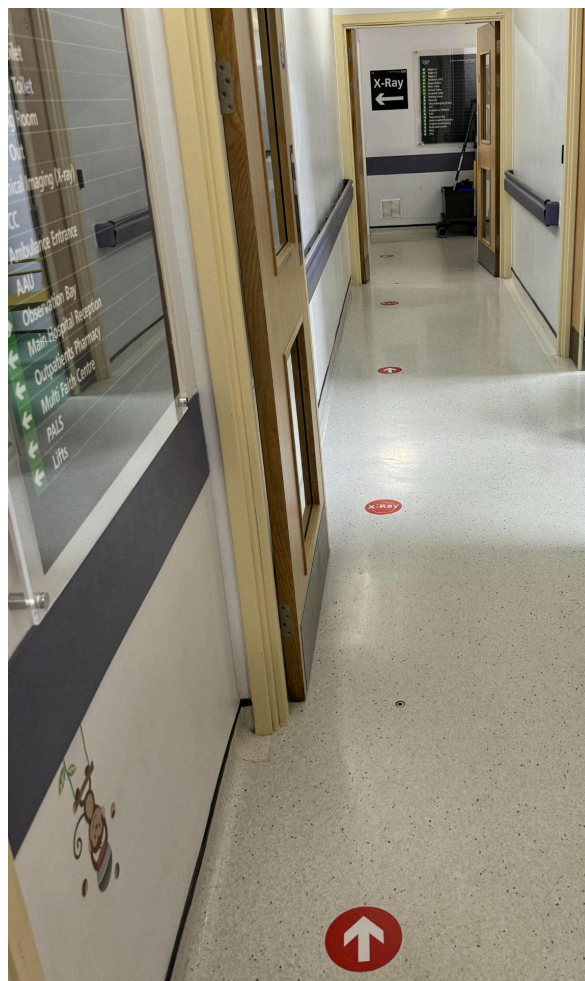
Floor markings indicating the route to the x-ray department after the locked door in the ED.
